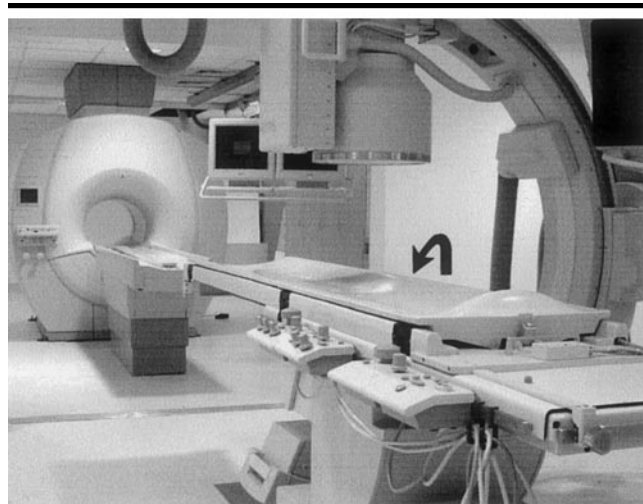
Interventional MR imaging and angiography suite used in the present study. The two adjoining units are connected by a sliding table (arrow), which allows transport of a subject from one unit to the other without changing position.
